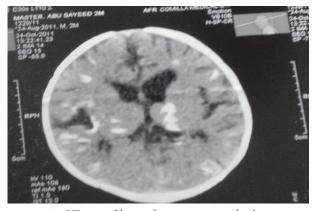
CT scan of brain showing intracerebral calcification, cerebral atropy and ex-vacu dilatation
